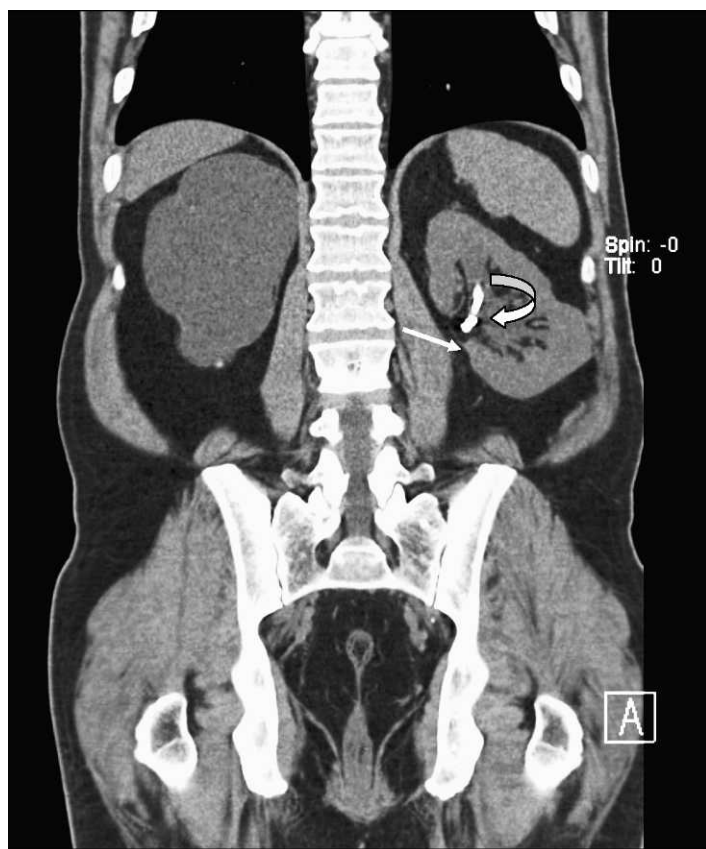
Coronal computed tomography in soft tissue window. Left ureteral stent (curved arrow) and eroded embolization coil (straight arrow) are noted within the left renal pelvis. On this window setting, these are difficult to tell apart.
